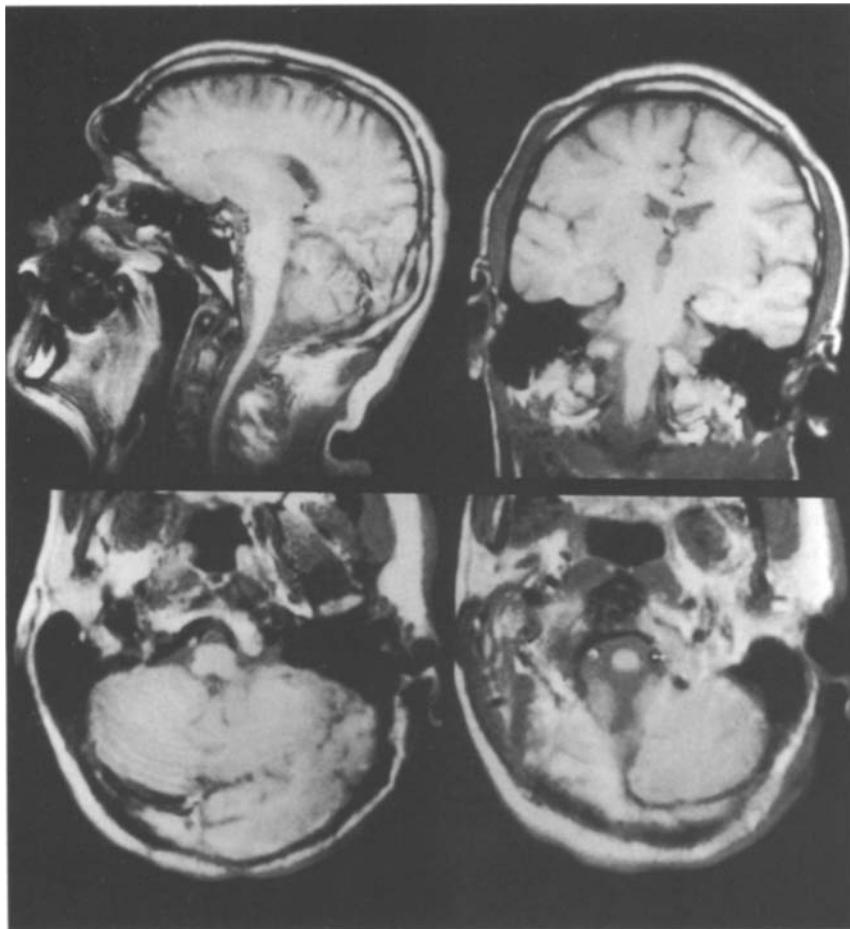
In contrast to Fig. 3, T1-weighted images of a patient with Friedreich's ataxia demonstrating atrophy of the upper parts of the spinal cord
